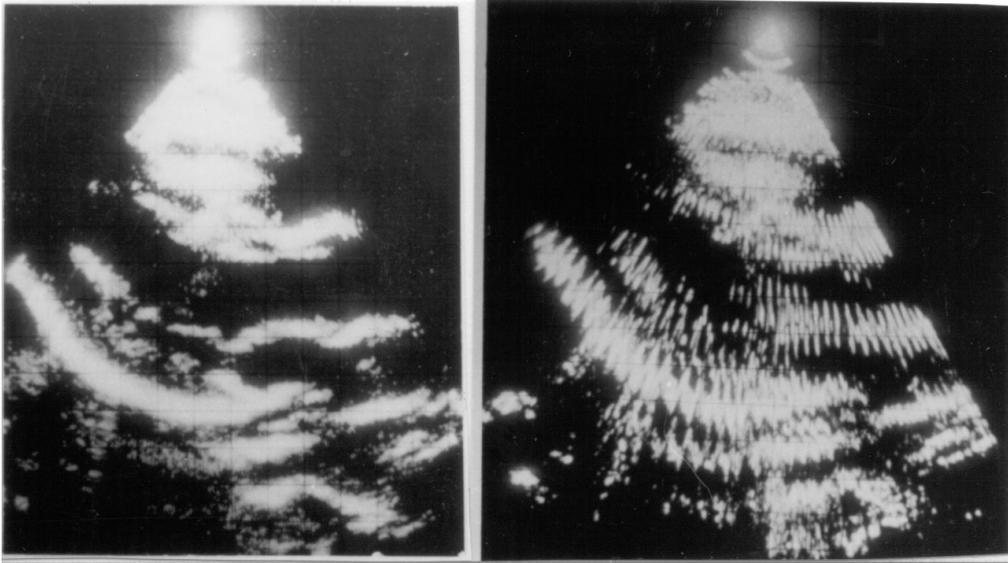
Ultrasono-tomokymogram (right) and ultrasono-cardio-tomogram (left) for normal hearts.
